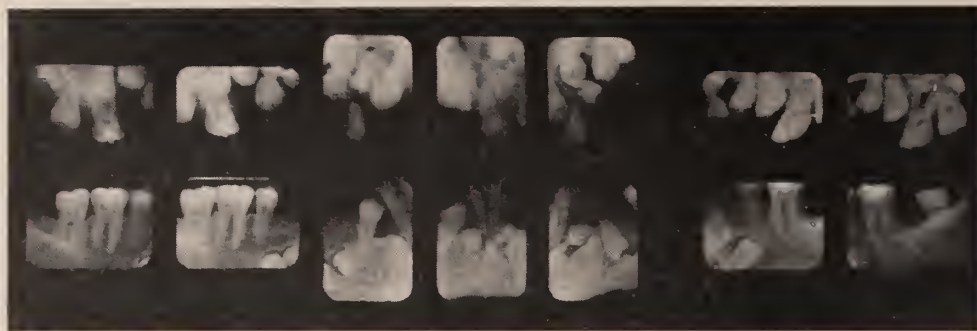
Dental roentgenograms showing numerous unerupted and impacted teeth and their irregular arrangement.
